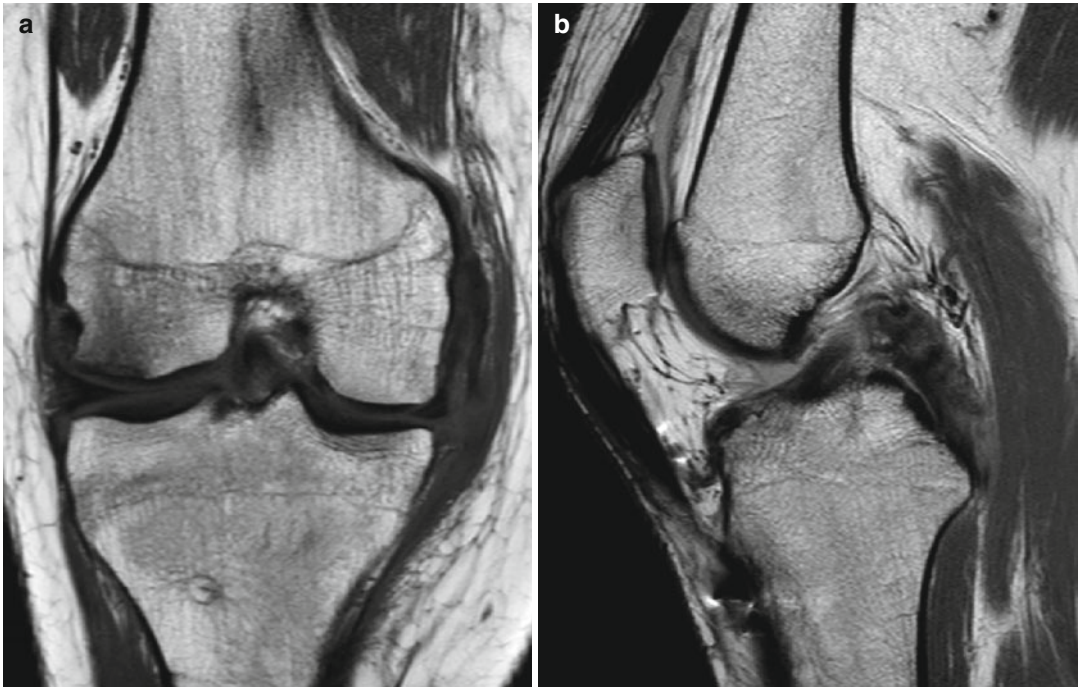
MRI demonstrates the exact definition of the anatomical injury. (a) Mid-substance injury of the MCL with disinsertion of the medial meniscus. (b) Mid-substance injury of the PCL and ACL
